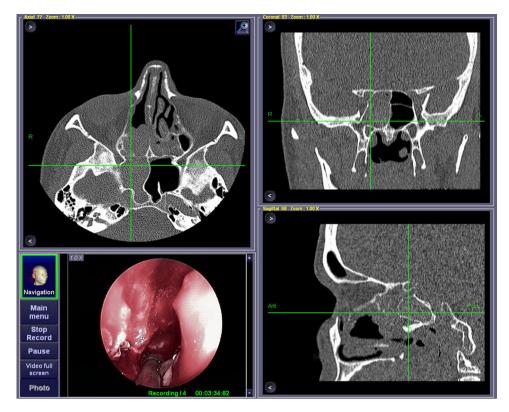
Neuronavigation. The neuronavigation control screen provides the surgeon with real-time navigation on the preoperative CT scan and provides information on anatomical relations with vital structures.
